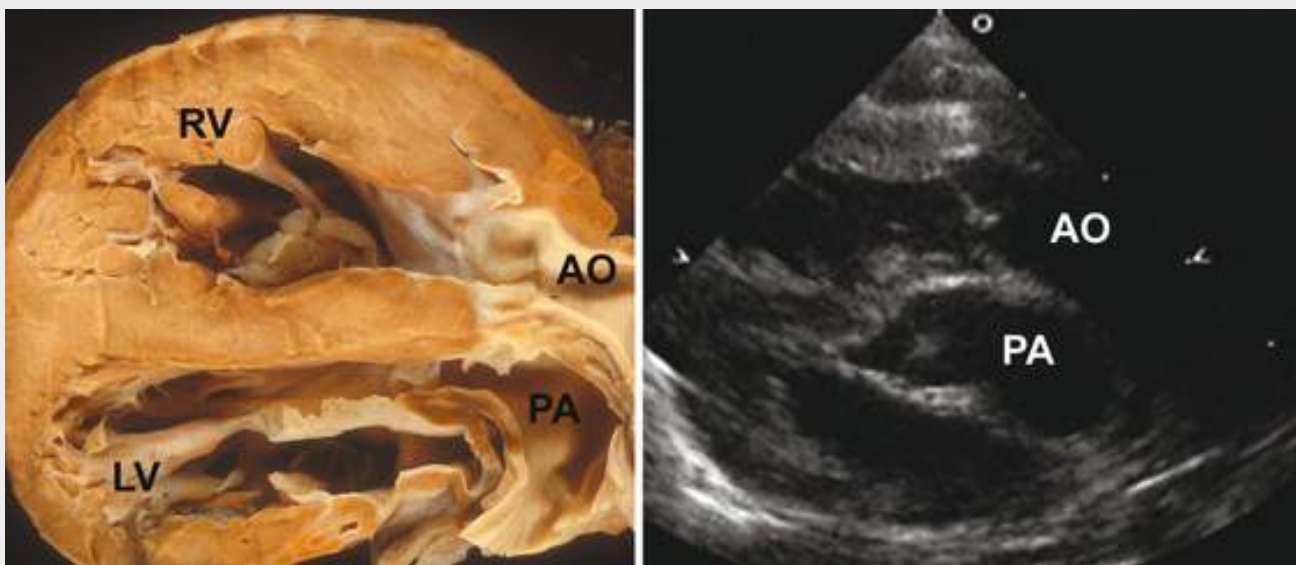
Parasternal long axis view in transposition of the great arteries. Note the parallel nature of the aorta and pulmonary artery. AO, aorta; LV, left ventricle; PA, pulmonary artery; RV, right ventricle.
